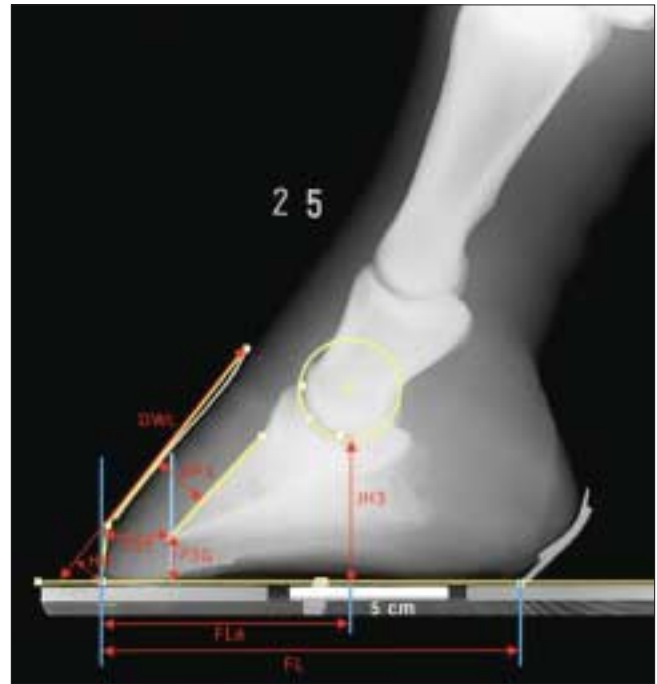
Hoof capsule parameters (distances) of the laterolateral radiograph. P3G: Tip of P3 to the ground, vertical distance from the tip of P3 to the horizontal line of the ground. P3T: P3 to toe, from the tip of P3 to the dorsal hoof wall, measured horizontally. JH3: P2-P3 joint height, from the coffin joint's center of rotation to the ground plane, minus the radius of the joint (JR3). FL: Foot width, the length of the hard hoof support at ground. FLA: Is not a parameter. The distance is used to calculate the percentage of Toe/Heel ratio (see Flat % in Fig 1). HD: Hoof Deviation, sum of the distances between the four points and the "hoof gauge line." HP3: Hoof-P3 distance, minimum distance between the dorsal mid-line of P3 and the exterior hoof wall. DWL: Dorsal wall length, from the hair line to the contact point with ground of the dorsal hoof wall.
